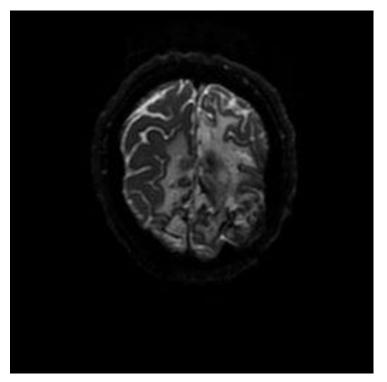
Postoperative MRI scan. Axial DWI does not visualize residual tumor tissue.
